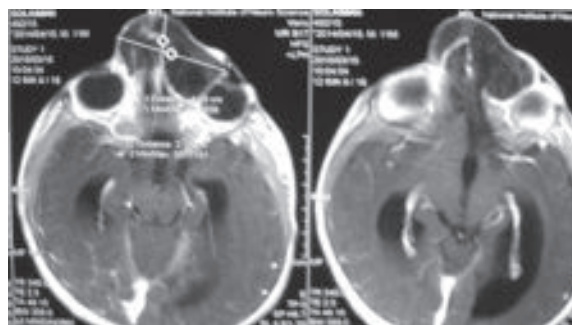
CT scan axial view showing anterior cranial base defect
